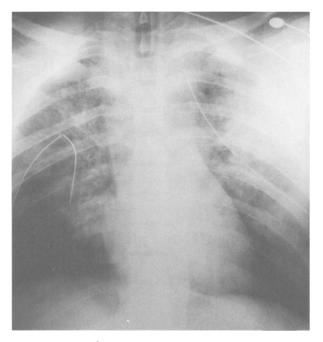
Case 1: second chest radiograph showing widened mediastinum.
